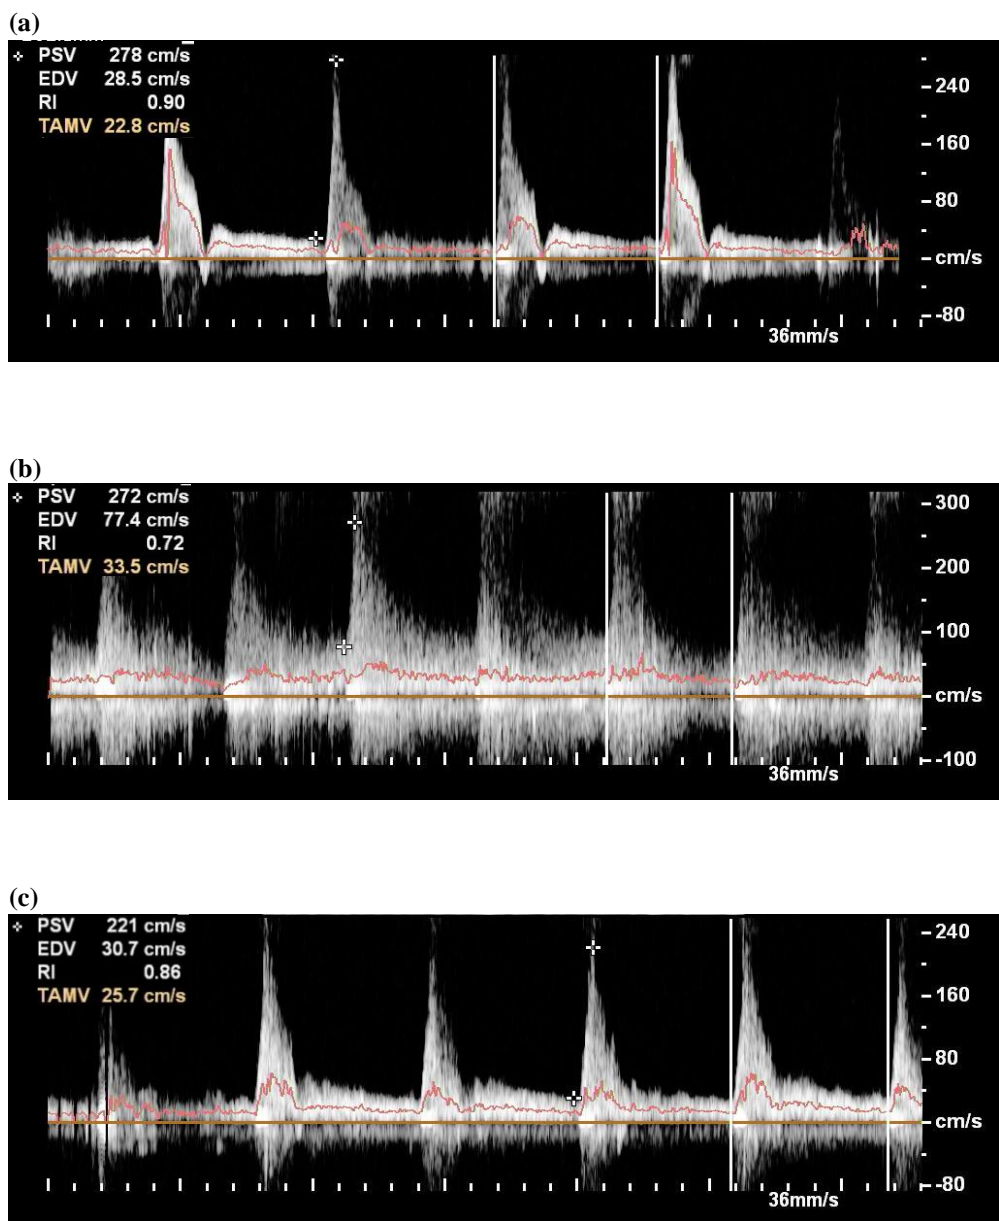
SMA Doppler US image at (a) fasting state, (b) 20 min, and (c) 50 min after meal ingestion in a 59-year-old man who underwent distal gastrectomy 30 months ago.
